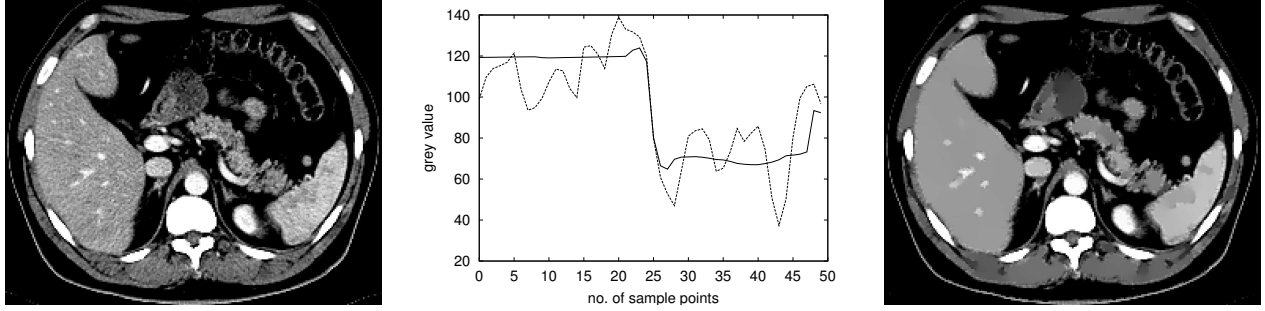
Effect of nonlinear diffusion filtering. Left: original unfiltered CT data. Middle: Unfiltered (dashed line) and diffusion-filtered (solid line) profiles. Right: diffusion filtered CT data.
